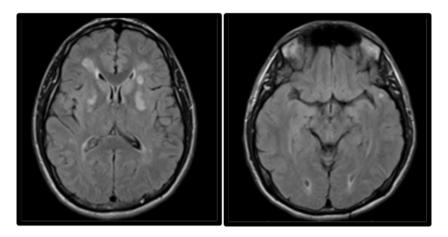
MRI study performed 2 weeks after symptom onset. Axial non-contrast FLAIR sequence showing persistent hyperintensity of the lesions affecting both lenticular nuclei, predominantly in the left hemisphere. The image also reveals hyperintensities in the subcortical white matter of both temporal poles, a typical finding in CADASIL.
